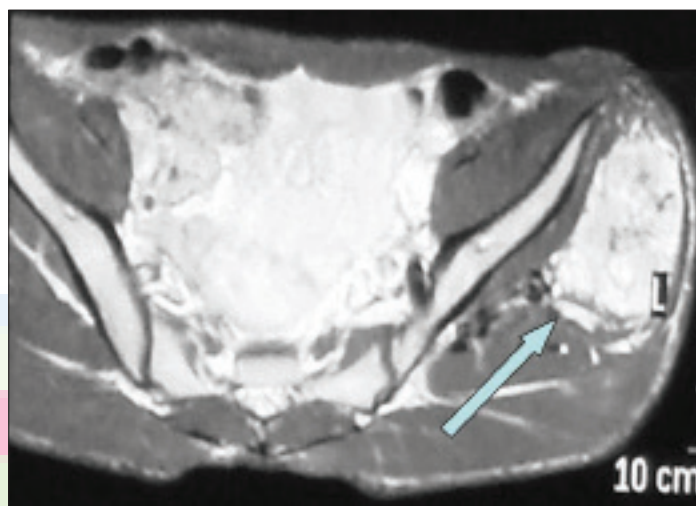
Magnetic resonance imaging T-2 weighted image showing the tumor in left gluteal muscles
